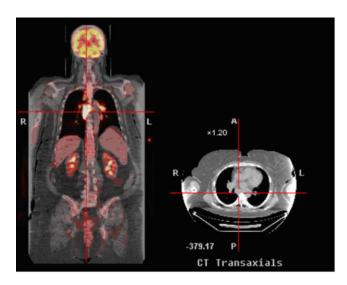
52-year-old female with sardoidosis. PET/CT coronal fusion image with corresponding axial CT of chest showing multiple enlarged mediastinal and hilar lymph nodes.
